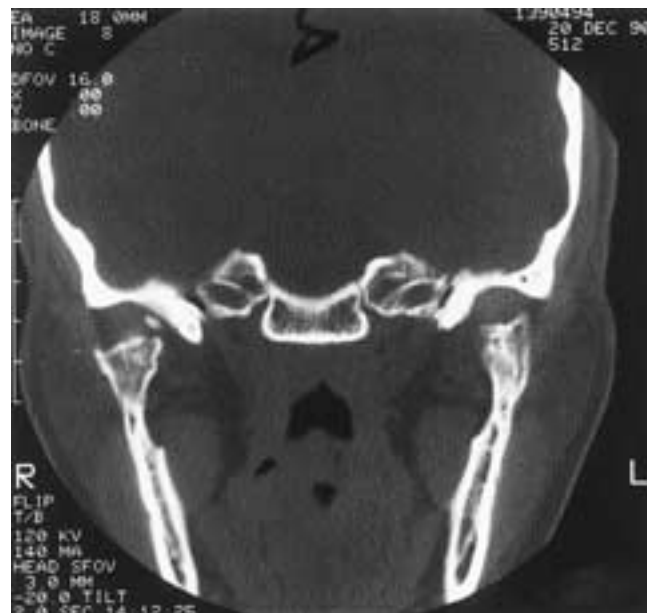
Bilateral costochondral grafts. Coronal CT scan of an asymptomatic patient with bilateral costochondral grafts. Note how the grafts are integrated into the ramus of the mandible. The most superior cartilaginous parts of the grafts are not well visualized on CT.
